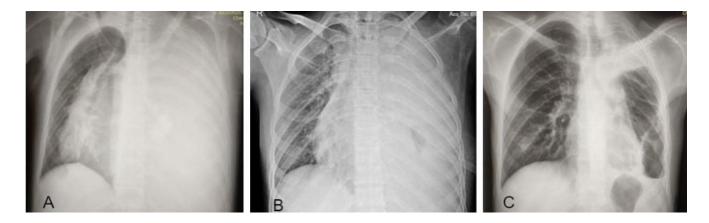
Chest X-ray PA view. A: complete white out of left hemithorax with mediastinal shift to the right, B: Dense opacity in left hemithorax with some aeration, C: 6-weeks post-surgery showing marked improvement with an air pocket in the left lower lobe.
